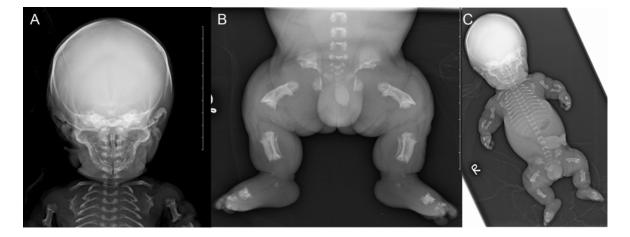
Full postmortem body X-ray of the fetus showing (A) macrocephaly and short upper limbs, (B) very short and shaped like "French telephone receiver" (C) platyspondylia, narrowed thorax and generally shortened long bones
